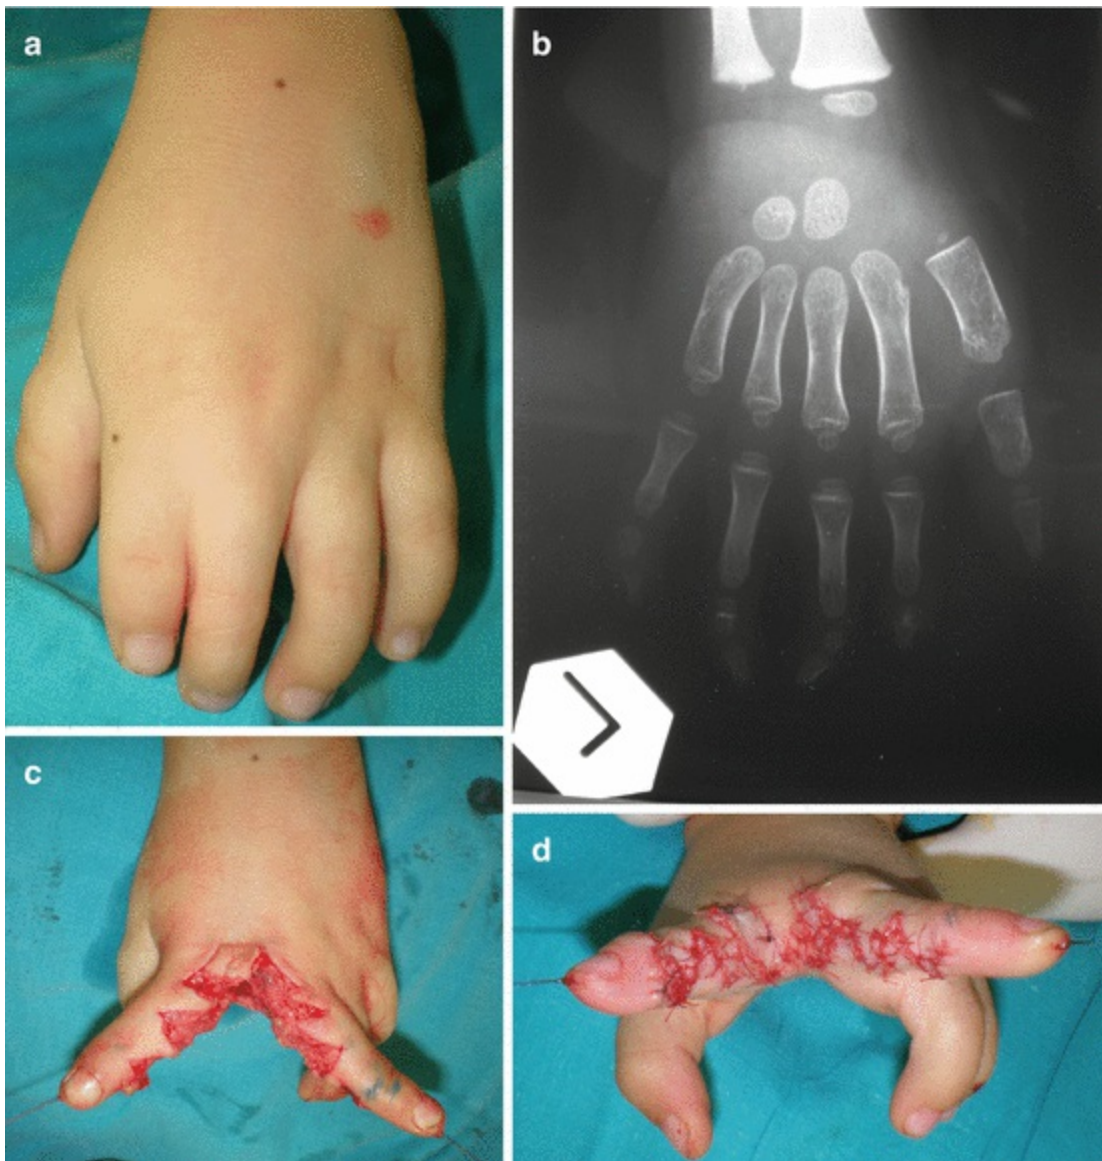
Brachysyndactyly in Poland's syndrome: (a) preoperative view; (b) radiography revealing anomalous fingers; (c) zig-zag incisions and web construction; (d) postoperative result
